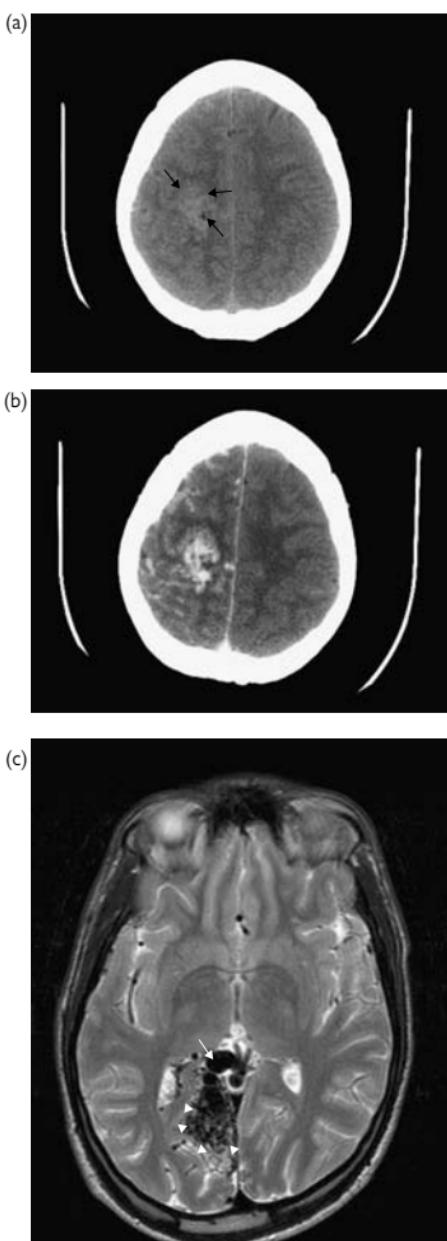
Arteriovenous malformation. (a) Non-enhanced CT; (b) contrast-enhanced CT; and (c) T2-weighted MRI. (a) Large area of ill-defined hyperdensity with little associated mass effect (black arrows). (b) Following contrast, multiple serpiginous enhancing structures are demonstrated in the centre of the hyperdense area and surrounding parenchyma in keeping with the nidus of an AVM. (c) Right occipital AVM with multiple focal and serpiginous flow voids (white arrowheads). There is little associated mass effect. Note the large draining vein entering the vein of Galen (white arrows).
